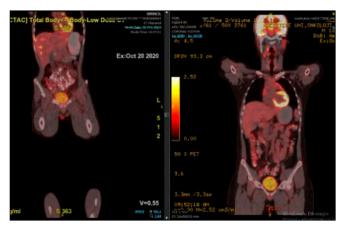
The left panel shows pre-treatment, and the right panel shows the FDG-PET images taken in the seventh month of treatment.
